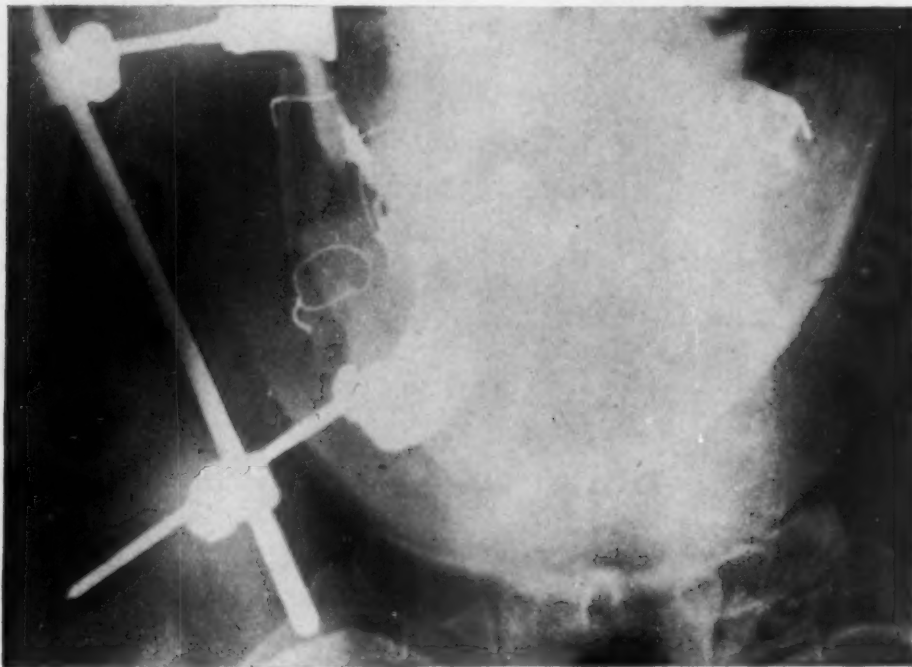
X-ray showing the bone graft in position, the fracture immobilized with peripheral bone clamp fixation, and the mandible by Jelenko splints.
